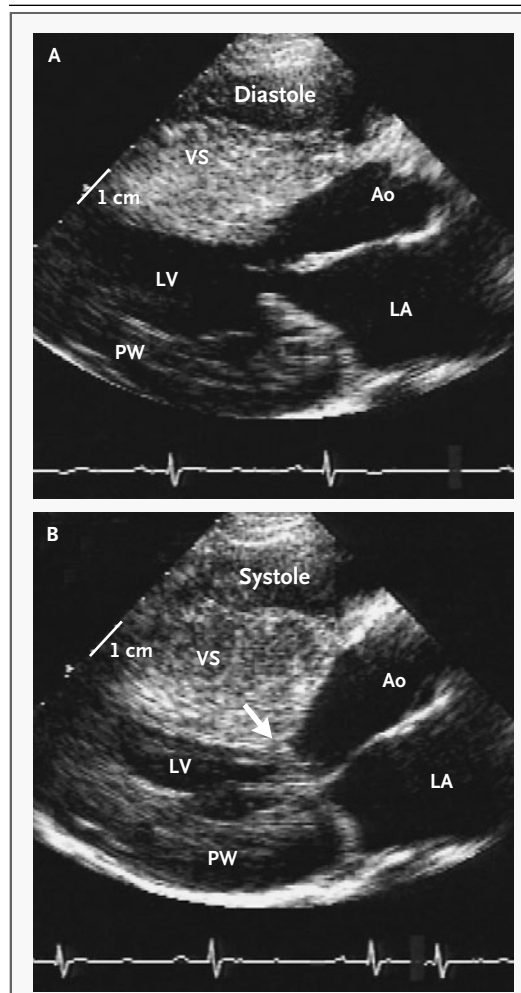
Two-Dimensional Echocardiogram from a Patient with Severe Symptomatic Hypertrophic Obstructive Cardiomyopathy.
